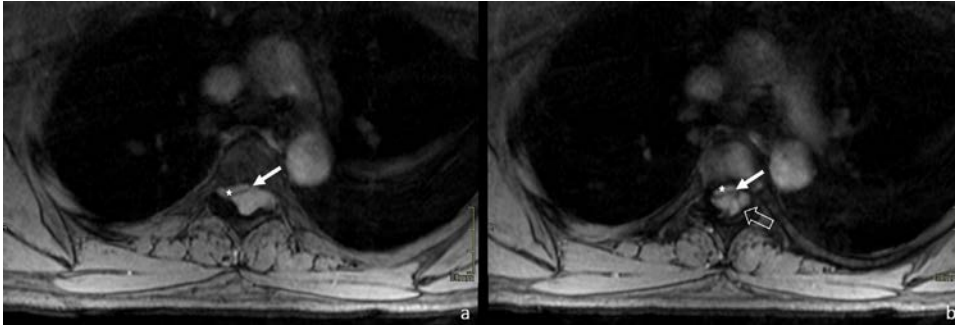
Axial T2-weighted images at the level of the T4-T5 intervertebral foramen (a) and the T5 vertebral body (b).
